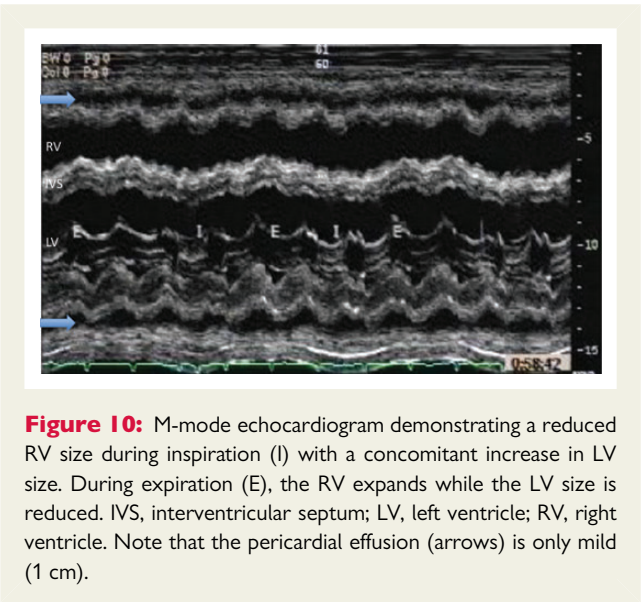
M-mode echocardiogram demonstrating a reduced RV size during inspiration (I) with a concomitant increase in LV size. During expiration (E), the RV expands while the LV size is reduced. IVS, interventricular septum; LV, left ventricle; RV, right ventricle. Note that the pericardial effusion (arrows) is only mild (1 cm).
